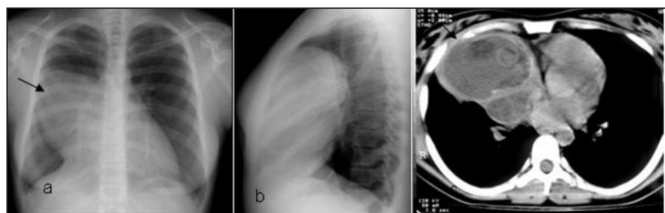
Posteroanterior (a) and lateral chest radiograph (b) of a 34-year-old male patient shows a large, smooth edged opacity, giving silhouette right heart border (arrow). CT (c) scan shows a large, heterogeneous fatty mass
